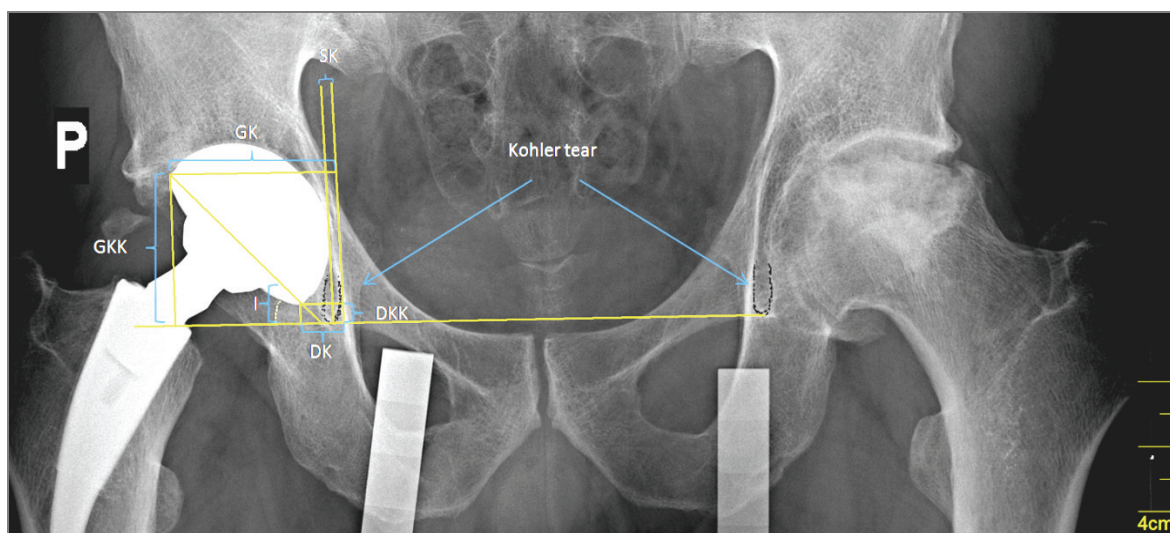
Acetabular cup position parameters on X-ray.
